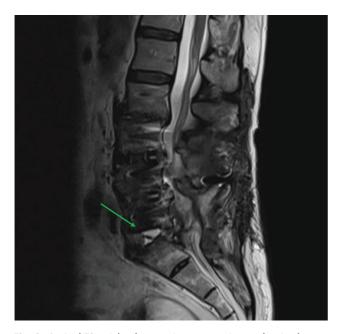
Sagittal T2-weighted magnetic resonance image showing hypersignal at the L5-S1 disc space referring to the local fluid collection.
